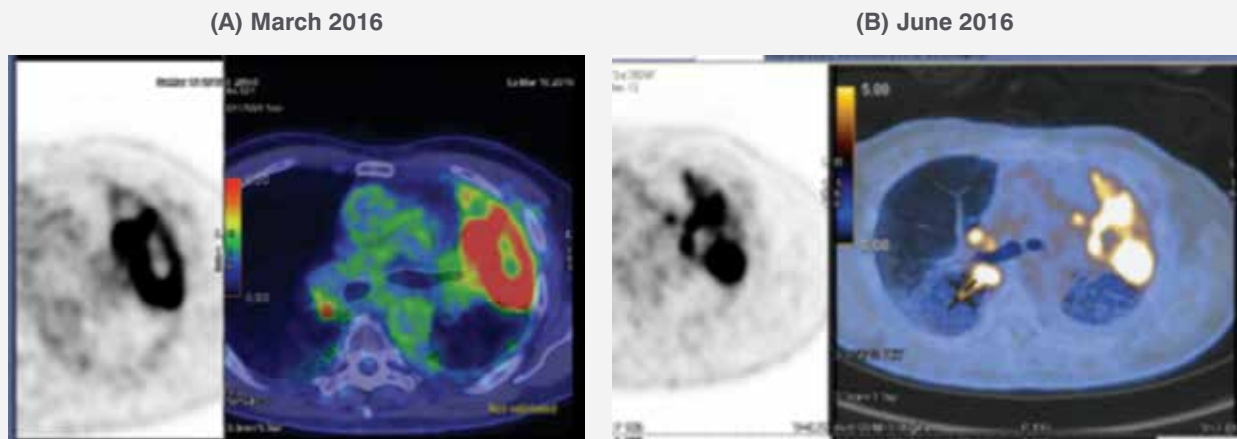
Thoracic PET-CT scans at 4 months (A) and 7 months after initiation of nivolumab treatment (B) showing stable disease after 3 further months of treatment
